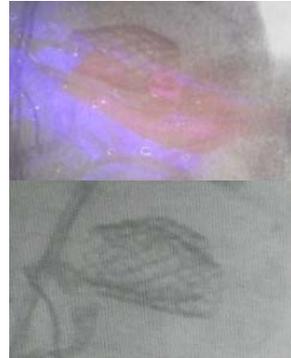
Serial intra-procedural radiographs of mesh opening and restoring vertebral height before augmenting with polymethylmethacrylate
